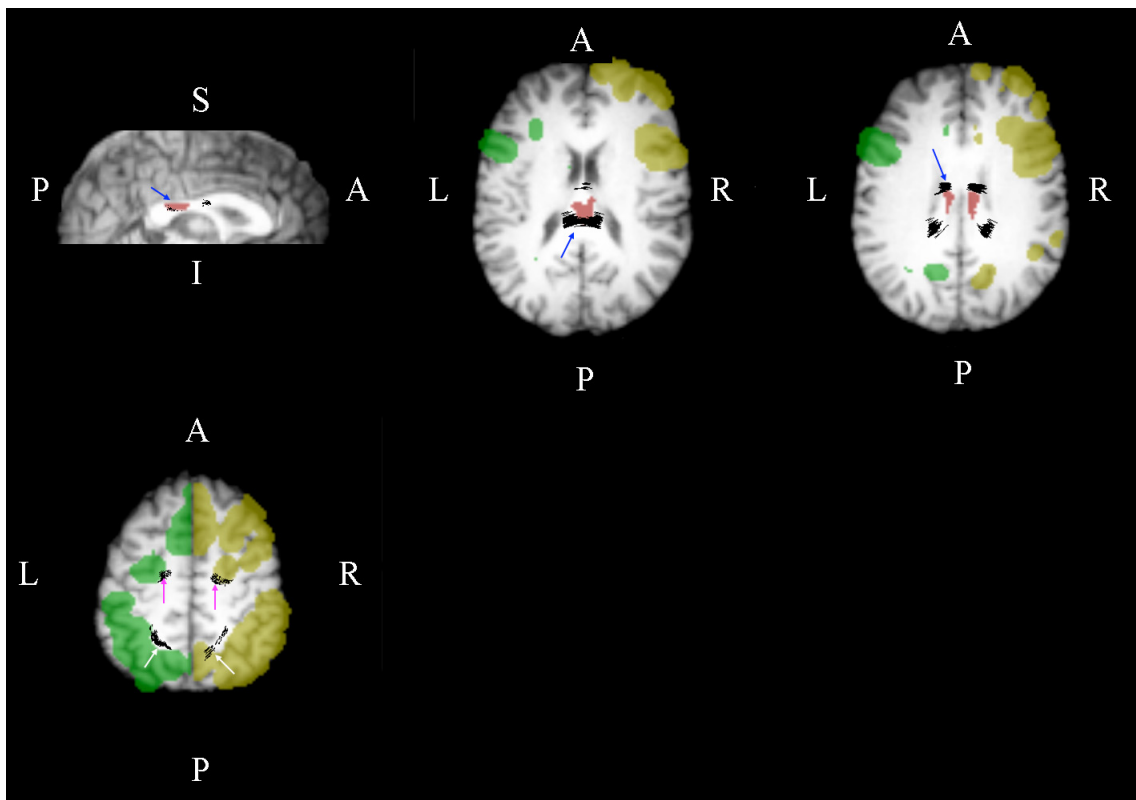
Functional MRI-guided tractography results for a representative participant (participant 1; green: left hemisphere gray matter activation ROI; yellow: right hemisphere gray matter activation ROI; red: corpus callosum activation ROI; black: tracts passing through all three ROIs; P: posterior; A: anterior; S: superior; I: inferior; R: right; L: left). The top images show fibres passing through corpus callosum activation in the sagittal view (left) and axial views (centre: isthmus activation; right: mid-body activation; blue arrows). The bottom image shows an axial view of tracts reaching targets in premotor cortex (magenta arrows) and parietal cortex (white arrows).
